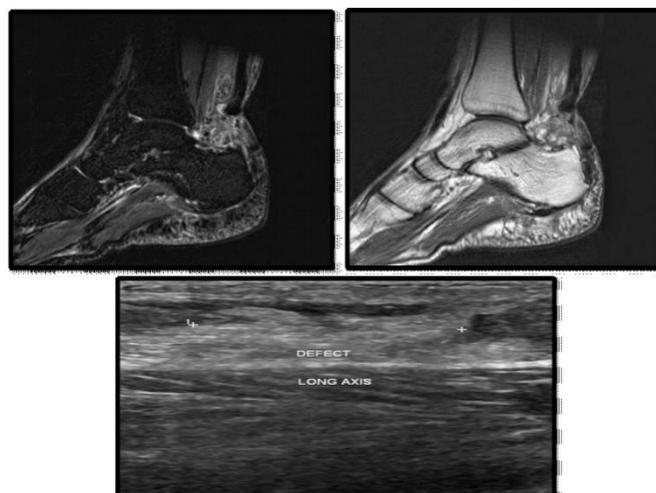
USG and MRI images showing a full thickness tear of the ten do Achilles with retraction of fibres
